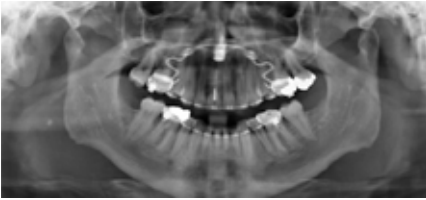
Panoramic radiograph after retraction of the anterior dentition showing bodily distalisation of the upper molars.
